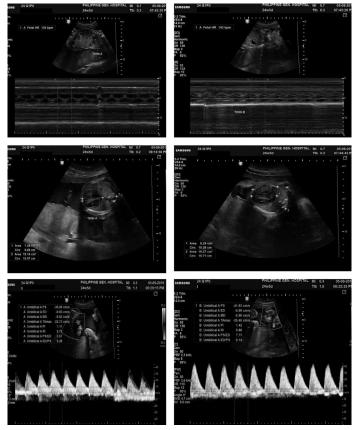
Ultrasound pictures of the twins
